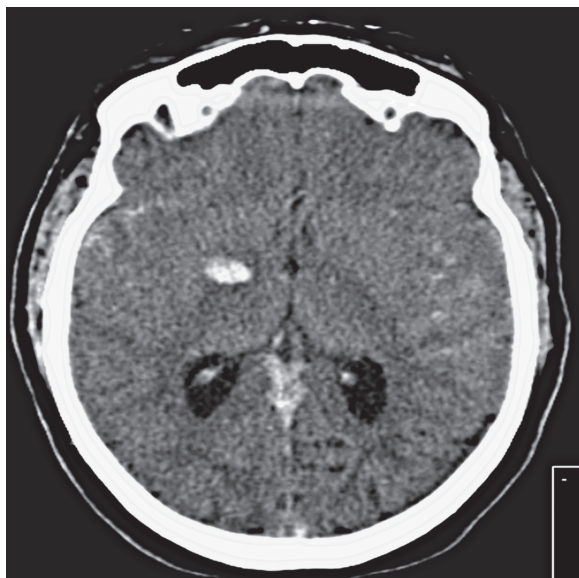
Preliminary CT. Non-contrast head CT prior to catheter directed treatment showing right basal ganglia hemorrhage, subarachnoid hemorrhage, and venous sinus thrombosis.
